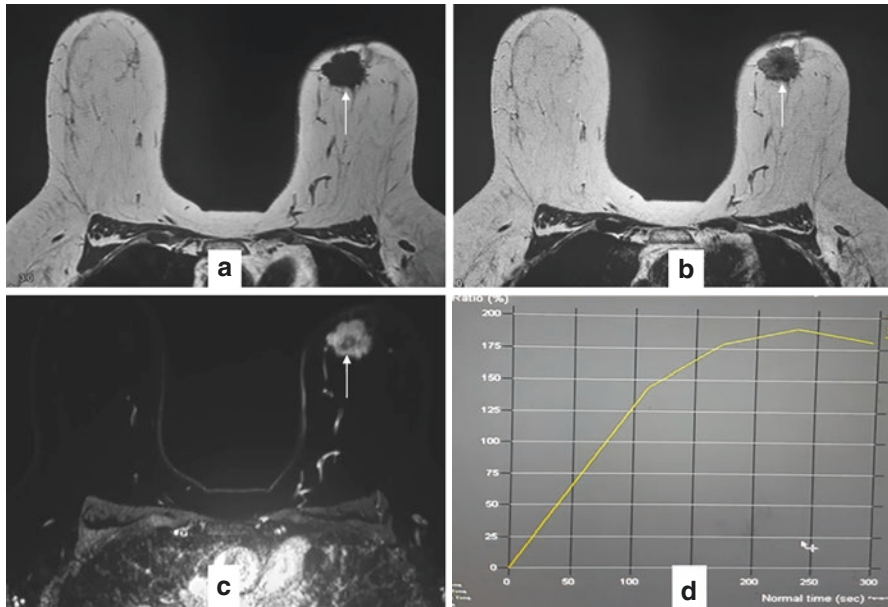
Imaging features of carcinoma on MRI: Spiculated hypointense mass on T1 and T2 weighted images (arrows in a, b) showing intense enhancement (arrow in c) and type III kinetic curve (d) raise high suspicion for malignancy
